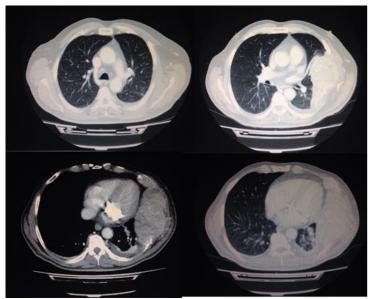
HRCT scan - gigantic left lung tumor with chest wall invasion
